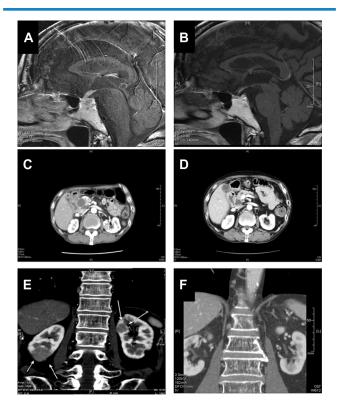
Pituitary MRI and abdominal CT pre- (A, C, E) and post- (B, D, F) replacement of hydrocortisone. After the treatment, almost all renal nodules (white arrows) disappeared and the pituitary stalk was shrinking.
